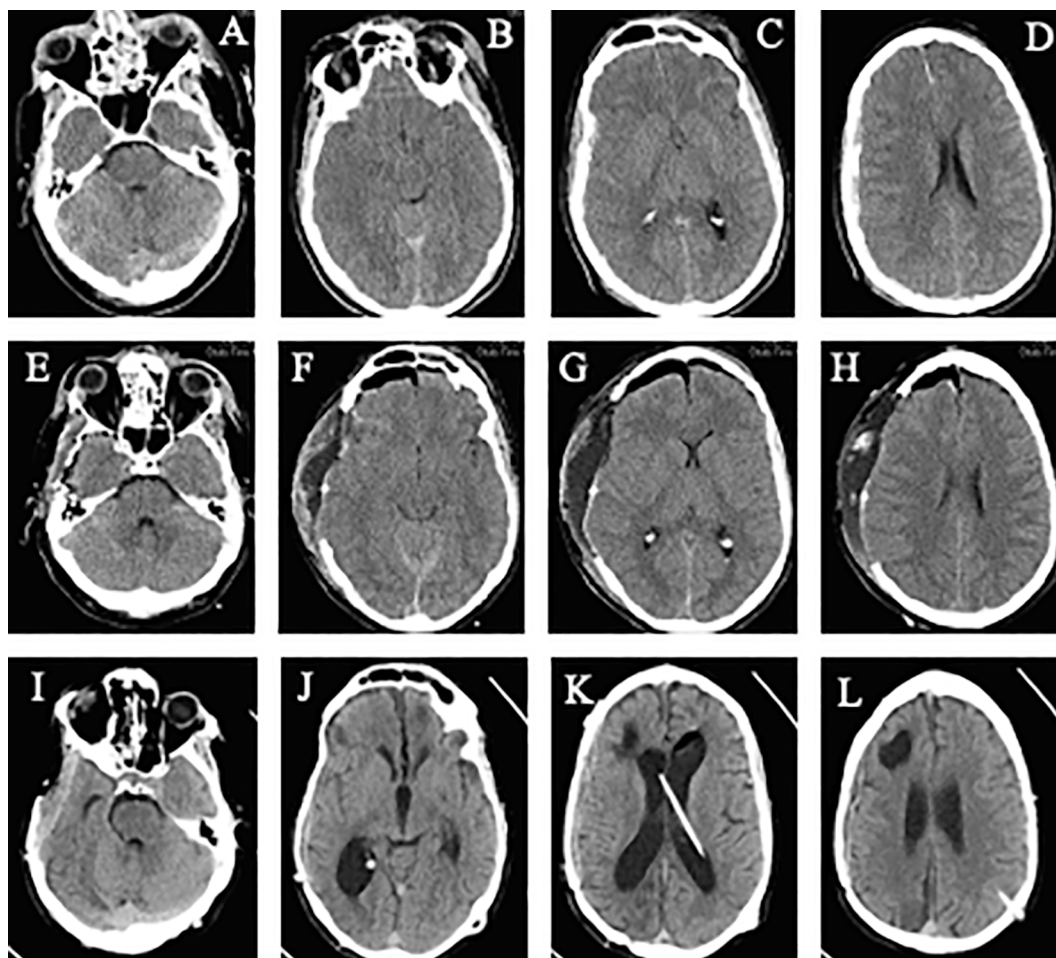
Non-contrast CT head images after traumatic brain injury. A-D: Head CT scan right after traumatic brain injury demonstrated multiple punctate hemorrhagic foci at the gray-white junctions involving bilateral frontal, temporal and occipital parenchyma suggestive of diffuse axonal injury, evidence of diffuse cerebral edema with increased intracranial pressure and mild leftward midline shift, small right cerebral convexity and parafalcine acute subdural hematoma, and small volume subarachnoid hemorrhage over bifrontal convexity. E-H: Head CT scan one day after injury showed status post right-sided decompressive craniectomy and evacuation of subdural hematoma with small volume pneumocephalus, improvement in the midline shift and patency of the cerebral convexity sulci, ongoing increased intracranial pressure with mild diffuse cerebral edema, and a possible focus of early ischemia in right anterolateral frontal cortex. I-L: Head CT scan four months post injury demonstrated mild hydrocephalus with a VP shunt placed via a left parietal approach (without transependymal CSF leakage), focal encephalomalacia in frontal, temporal and parietal lobes, a small right frontal porencephalic cyst, and stable subdural collections.
